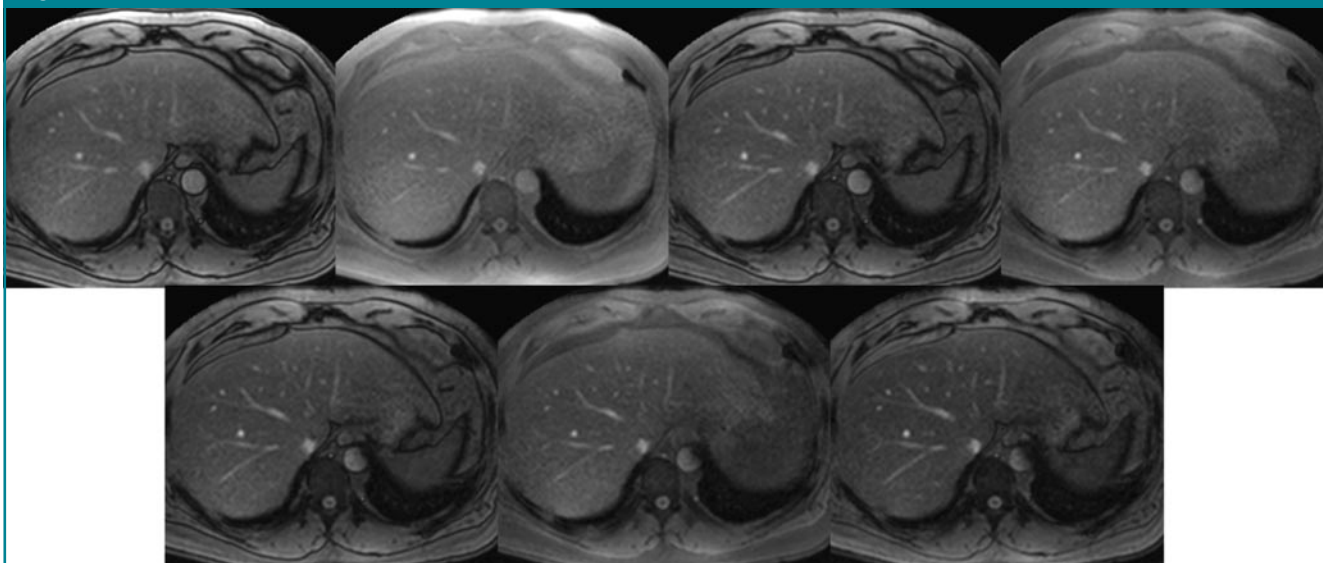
Transverse breath-hold multiecho MR imaging acquisition (17/1.15–8.05; flip angle, 20°; field of view, 320 mm; section thickness, 10 mm) in liver with seven readouts. Images are alternately out of phase and in phase from left to right in each row. Image quality is maintained throughout the range of echo times.
